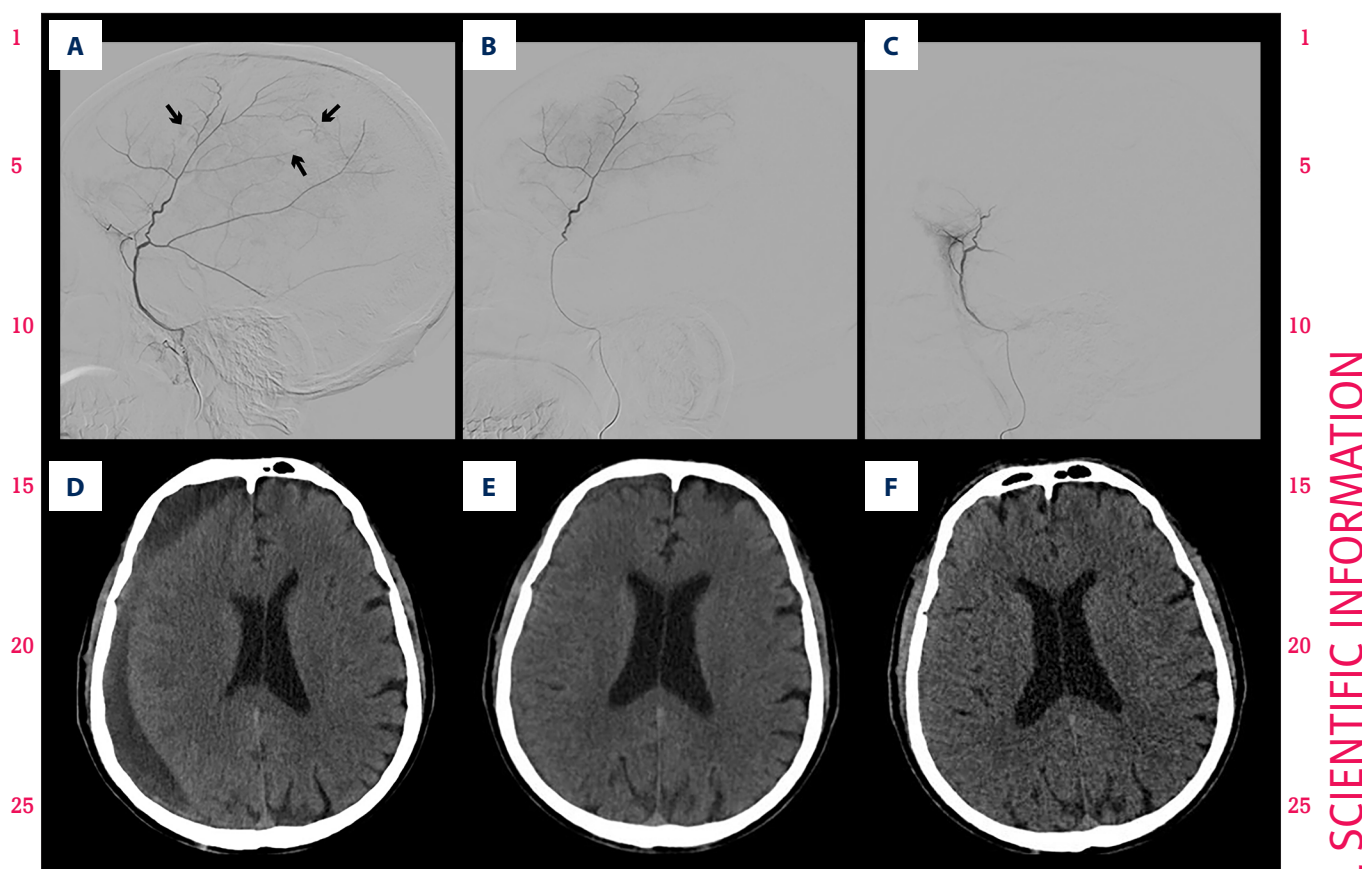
Representative case demonstrating progressive radiological resolution after middle meningeal artery embolization. (A) Pre-embolization angiography shows hypertrophied branches (arrows) of the middle meningeal artery supplying the hematoma membrane. (B) Superselective catheterization of the anterior branch of the middle meningeal artery is demonstrated. (C) Post-embolization angiography demonstrates occlusion of the pathological vascular supply. (D) Baseline computed tomography (CT) reveals a chronic subdural hematoma with mass effect. (E) Follow-up CT at 1 month shows a significant reduction in hematoma thickness. (F) At 3 months, complete resolution of the hematoma is observed.
